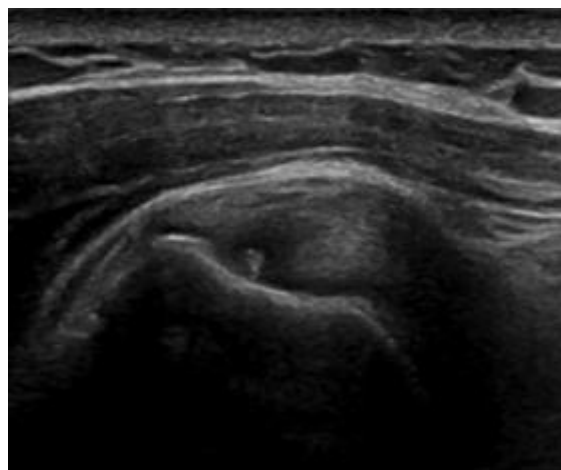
Longitudinal ultrasound shows a bulky supraspinatus tendon with calcification at the insertion site - Tendinopathy.
